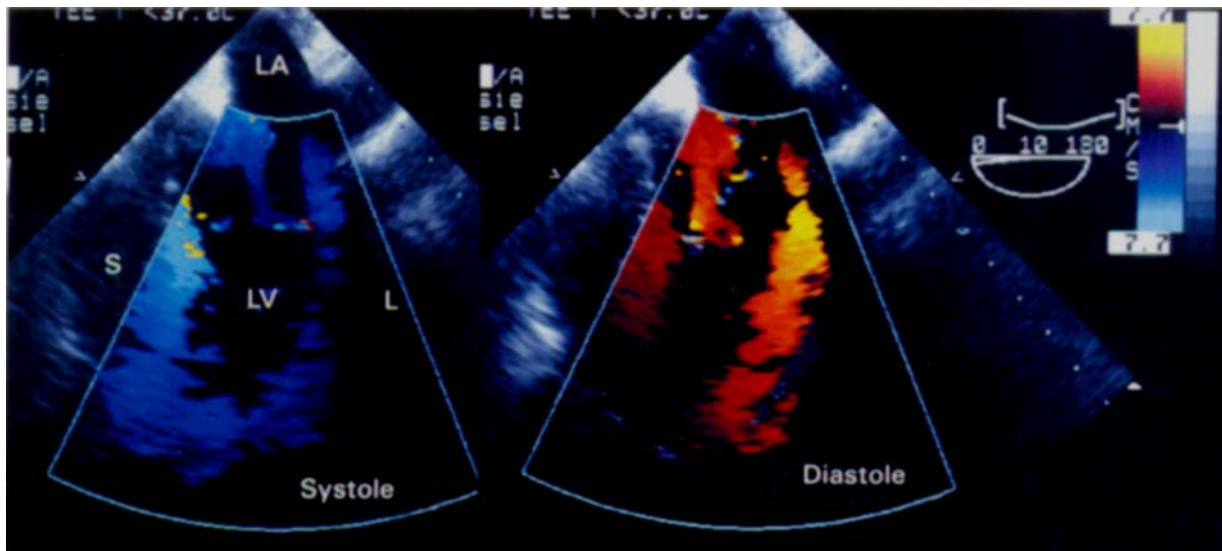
Myocardial colour tissue Doppler imaging of the left ventricle (LV) in mid-oesophageal four chamber view. A colour coded velocity map is superimposed on the two-dimensional image. During systole, the shortening of longitudinal fibres results in a motion that is directed toward the apex, away from the transducer, and is therefore coded blue. During diastole the myocardium moves back toward the base of the LV and is coded red. The greater the velocity, the brighter the colour. The encoded velocity information can be extracted from any site of interest and displayed as a time-velocity waveform.
